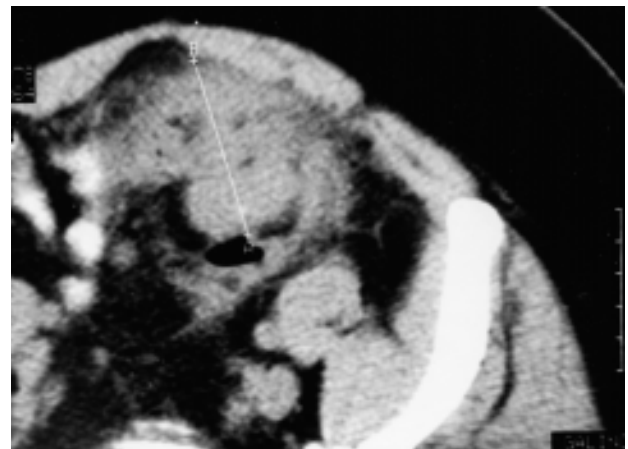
Abdominal CT scan showing pericolic abscess (5 cm in its greater diameter) located in the left iliac fossa deriving from acute diverticulitis.
